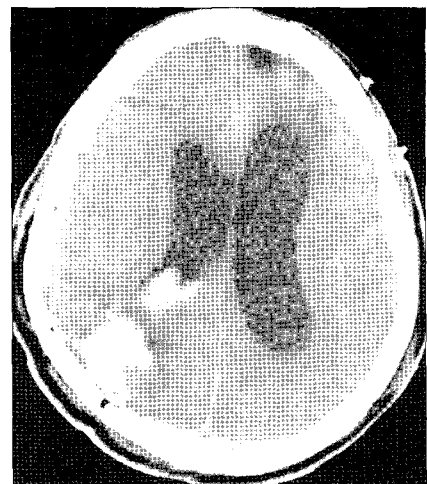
The second postoperative brain CT showing the removed acute epidural hemorrhage and a slightly decreased amount of hemorrhage along the shunt tube, and improvement of the subfalcine herniation.
